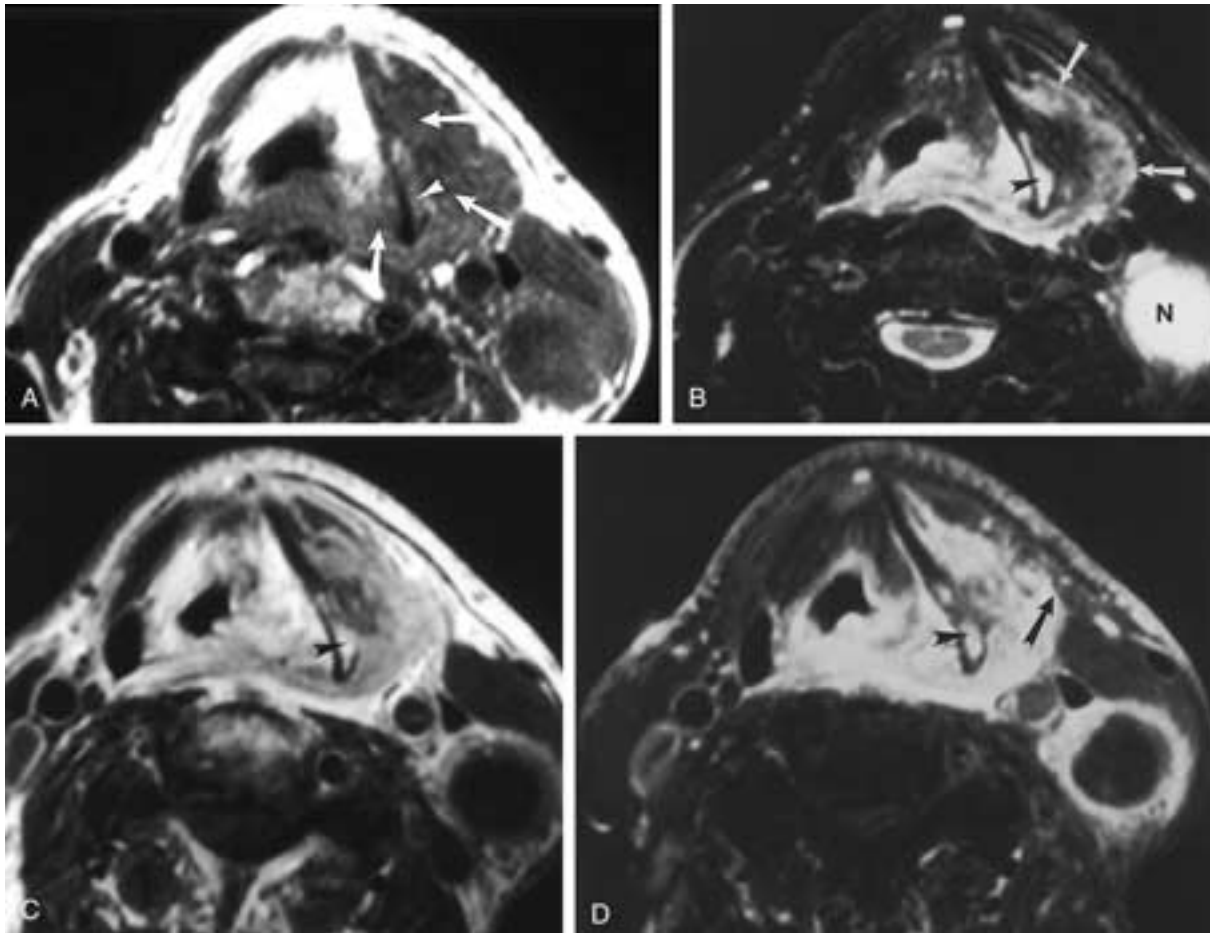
Carcinoma of the pyriform sinus invading the posterior thyroid cartilage and extending along the outer surface. A, Axial T1-weighted image without contrast. The tumor (*arrows*) is poorly seen relative to the strap muscles. Note the intermediate signal intensity (*arrowhead*) of the posterior thyroid cartilage. B, T2-weighted FSE image with fat suppression. The margins of the tumor (*arrows*) can be seen more distinctly. Note the high signal (*arrowhead*) within the posterior thyroid cartilage, indicating that it is abnormal. Note the abnormal node (*N*). C, Postcontrast without fat suppression T1-weighted image shows enhancement within the cartilage (compare with the T1-weighted image) and enhancement of the tumor. Enhancing thyroid cartilage (*arrowhead*). D, Postcontrast T1-weighted image with fat suppression. The margin of the tumor relative to the muscle (*arrow*) is clearly defined. Because fat suppression is used, the high signal within the thyroid cartilage (*arrowhead*) is not fat and is thus presumed to be abnormal. Again, note the metastatic node.
